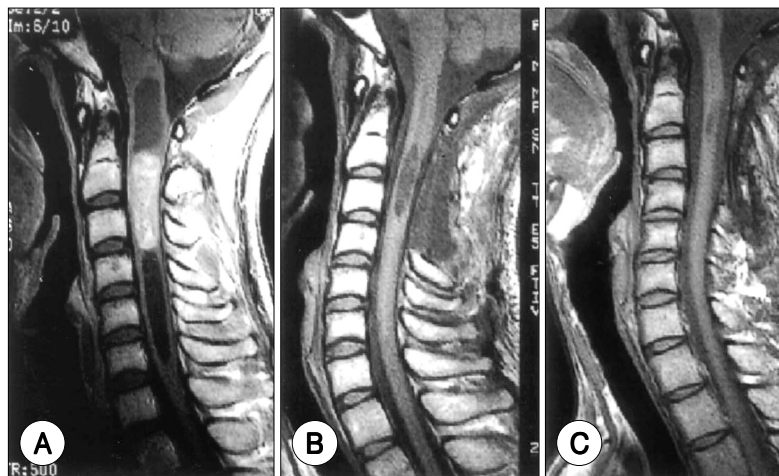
Serial MRI follow up in an ependymoma patient
